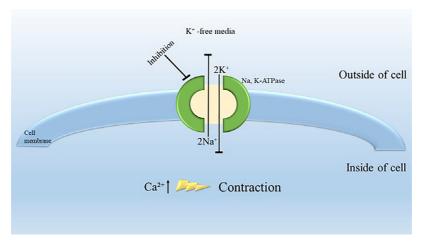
Sodium/potassium ATPase inhibition and low-frequency ultrasound.
